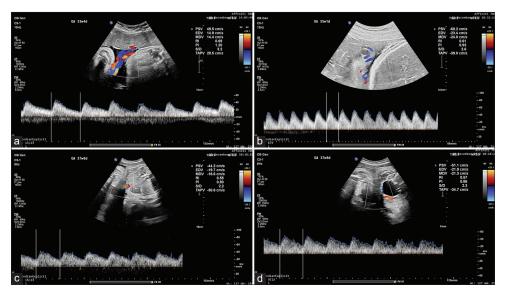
Umbilical artery Doppler wave pattern at different sites. (a) Duplex Doppler ultrasound image of 33-week 4-day fetal umbilical artery sampled at placental attachment site showing normal wave pattern. (b) Duplex Doppler ultrasound image of 35-week 1-day fetal umbilical artery sampled at free loop showing normal wave pattern. (c) Duplex Doppler ultrasound image of 37-week 6-day fetal umbilical artery sampled at abdominal attachment site in axial section showing normal wave pattern. (d) Duplex Doppler ultrasound image of 37-week 6-day fetal umbilical artery sampled beside the bladder in axial section showing normal wave pattern
